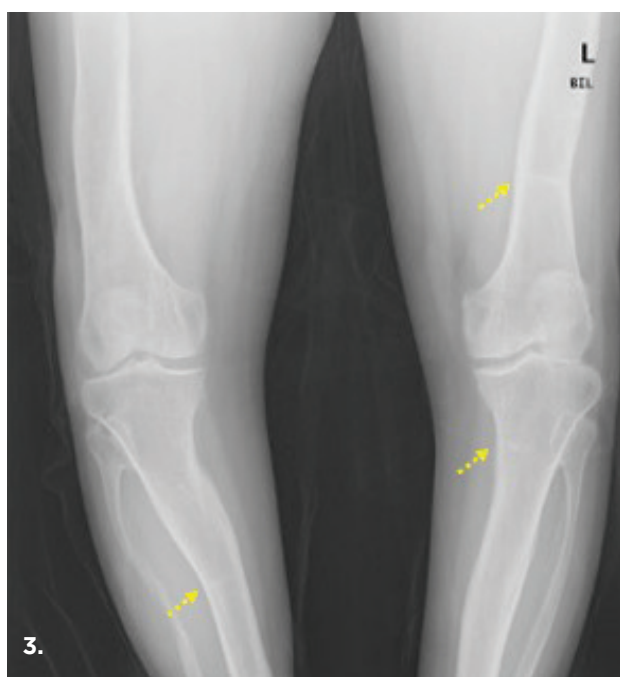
Radiography of long bones revealing a transverse radiolucent line with irregular sclerotic edges, consistent with a pseudofracture (“Looser zone”) in the right femoral diaphysis (arrow). Signs of previous lengthening procedures are detectable (dotted arrow).
